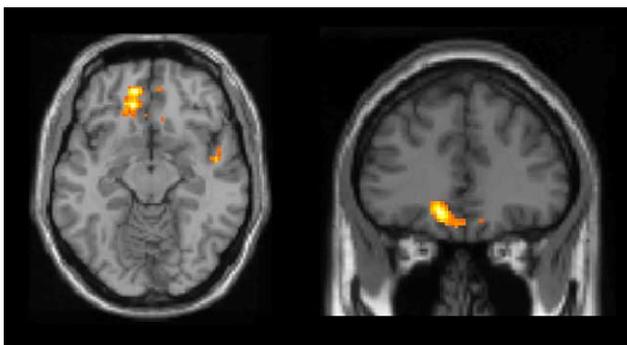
Left medial orbitofrontal cortex activation cooperation. Clusters are superimposed on horizontal ($z = -12$) and coronal ($y = 36$) MRI sections.
